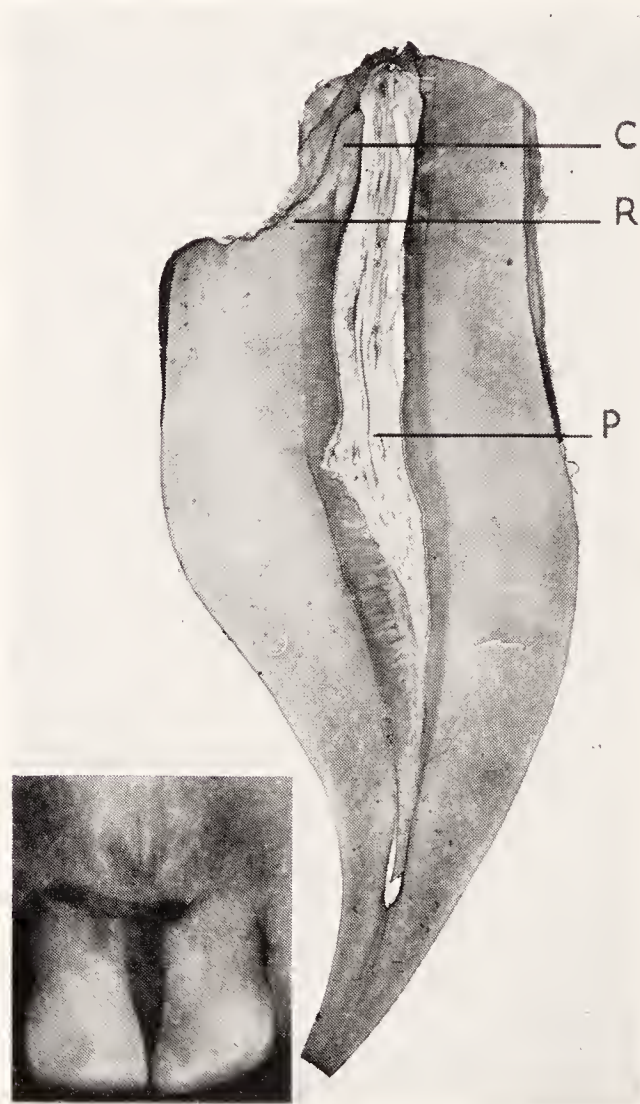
Resorption of the roots of the upper central incisors of a man, aged fifty years. Radiographically the roots appear very short. Clinically the teeth were moderately loose. *P*, pulp; *R*, resorption on the root; *C*, cementum covering the resorbed root surface.
